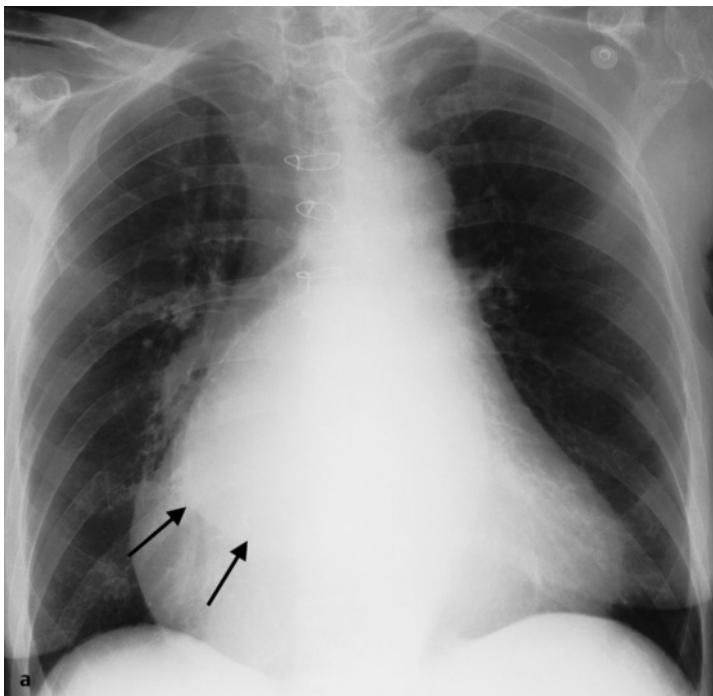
a,b Atrial double shadow after surgical correction of a mitral valve defect. Massively enlarged left atrium in generalized enlargement of the heart. The tracheal bifurcation is widened and an atrial double shadow (black arrows in a) is visible. No decompensation. Sternal wire cerclage after mitral valve replacement. Findings include tracheobronchopathia calcarea and barrel chest indicative of chronic obstructive pulmonary disease. The coronal view of the 3D CT (b) reconstruction of the tracheobronchial tree shows a massively widened bifurcation angle measuring 120°.
